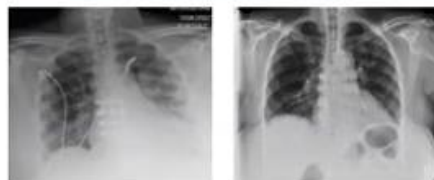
Chest radiograph on admission (left) showing patchy airspace disease and pleural effusion in the dependent left lung base, with patchy interstitial pneumonitis in the mid-right lung. Chest radiograph at transfer from ICU (right) showing interval improvement in pulmonary aeration with mild remaining reticulonodular infiltrates bilaterally.
